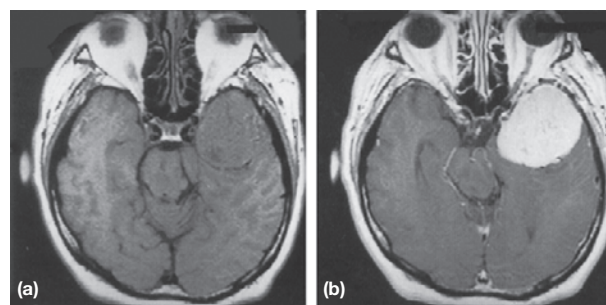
Dementia with meningioma. (a) T1-weighted and (b) gadolinium-enhanced T1-weighted MRI of the brain of a 65-year-old woman, showing a large, contrast-enhancing mass lesion in the left lobe that compresses the left hippocampus and displaces the midbrain.
